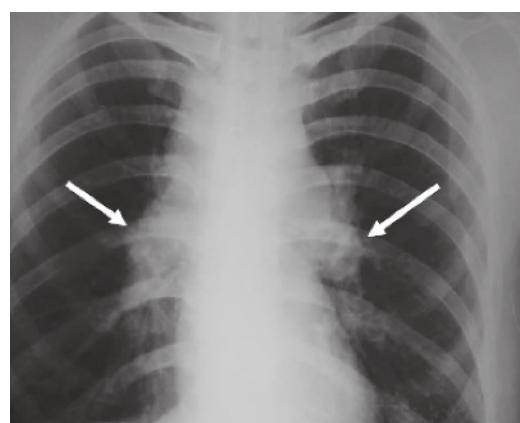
Plain radiograph of chest showing bilateral hilar lymphadenopathy in a patient with an acute form of sarcoidosis called Lofgren syndrome
